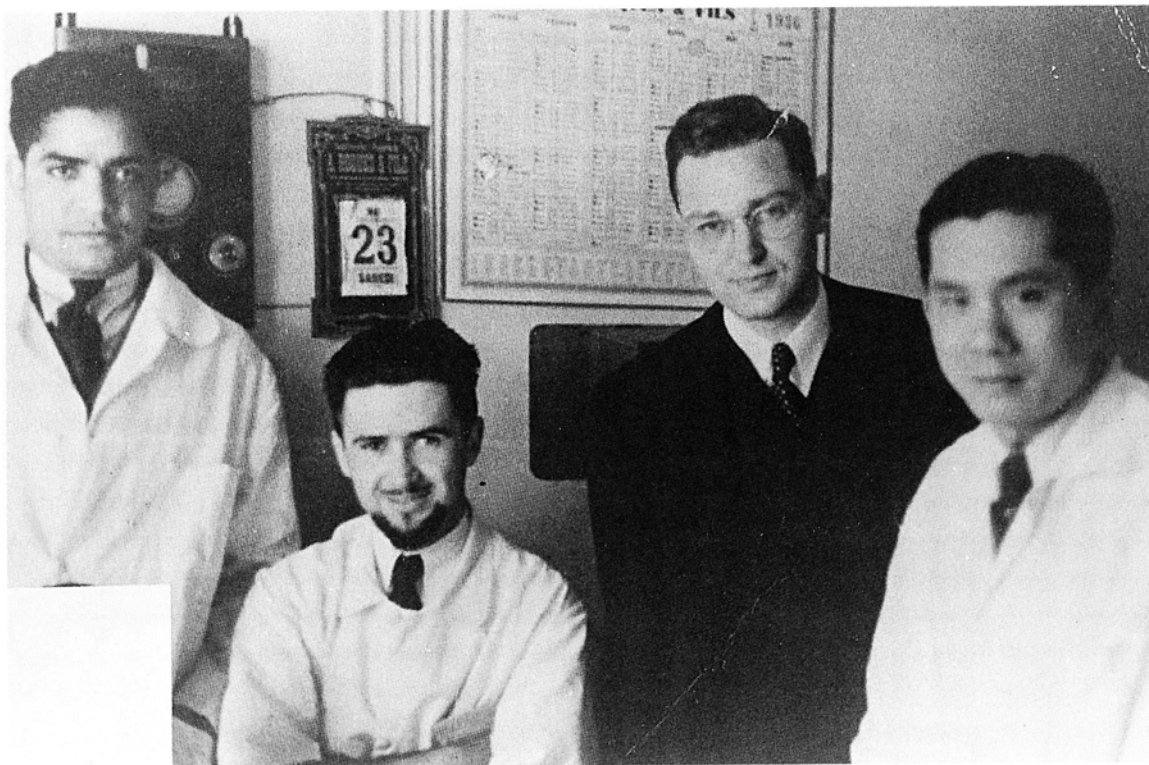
Standing behind assistant roentgenologist J.A. del Regato, *stagiers* Reindal Assad of Haiti, Simeon T. Cantril of the U.S., and Paterno Chikiamco of the Philippines (1936).
